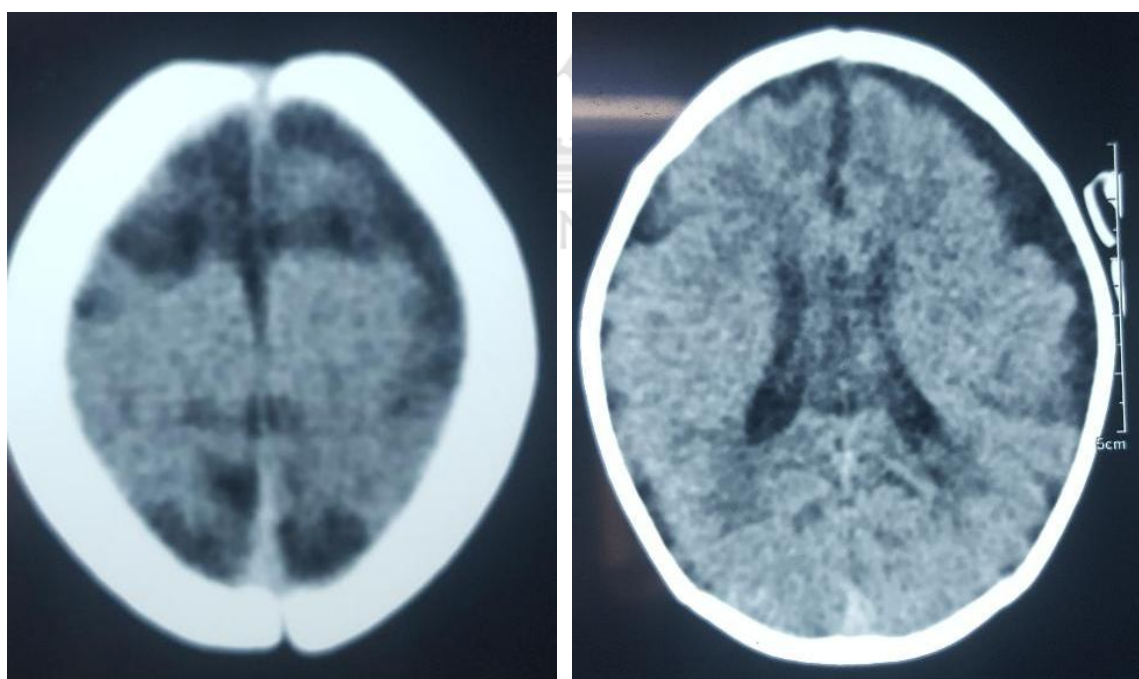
CT scan showing dilatation of ventricles increased subarachnoid space and cortical atrophy
